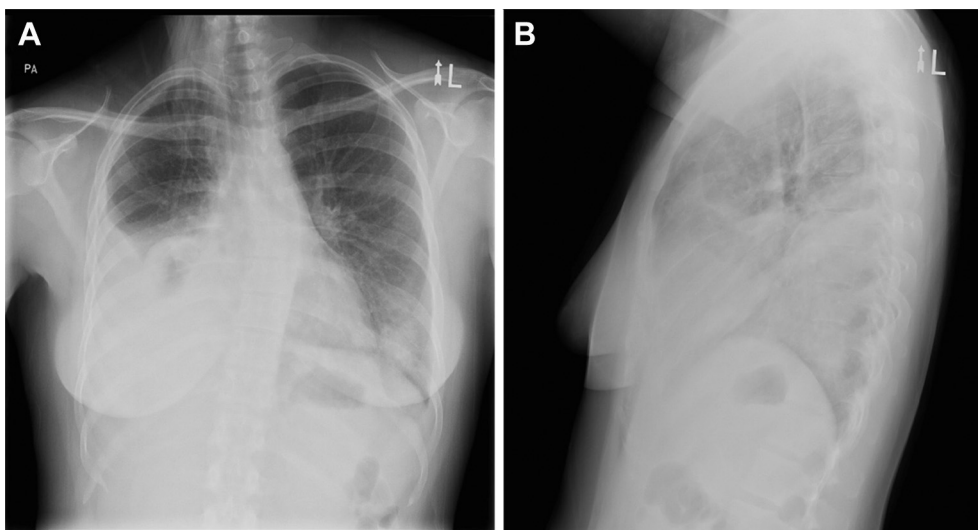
A, B, Chest radiograph with posterior-anterior (A) and lateral (B) views showing a large right pleural effusion with associated atelectasis.
